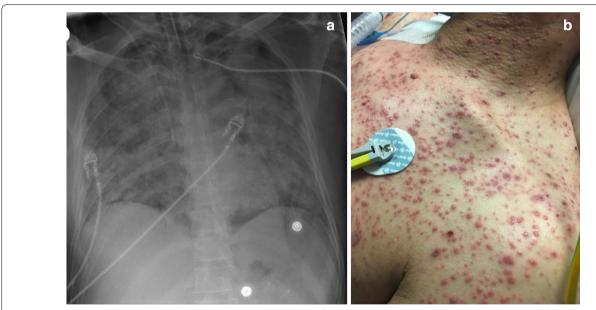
a Chest X-ray revealing a bilateral diffuse alveolar and interstitial infiltrates. b Diffuse vesicular cutaneous eruption with different ages lesions
